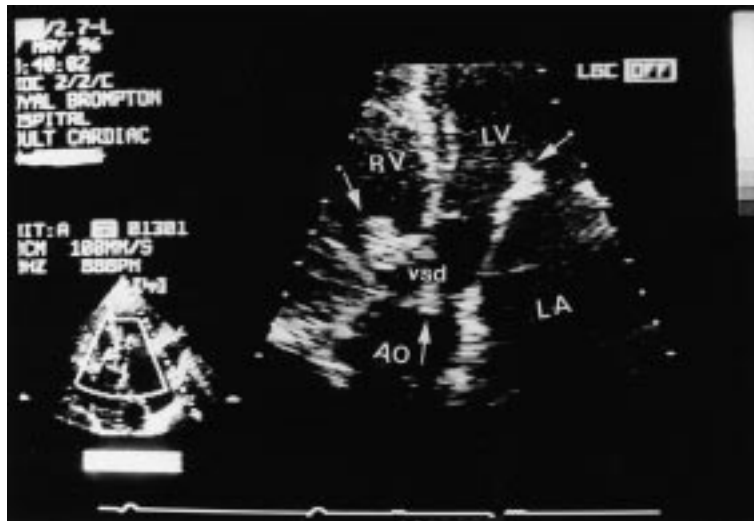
2D echocardiogram. Apical five chamber view of a patient with Eisenmenger ventricular septal defect. Arrow indicates vegetation on mitral valve, aortic valve and tricuspid valve.
